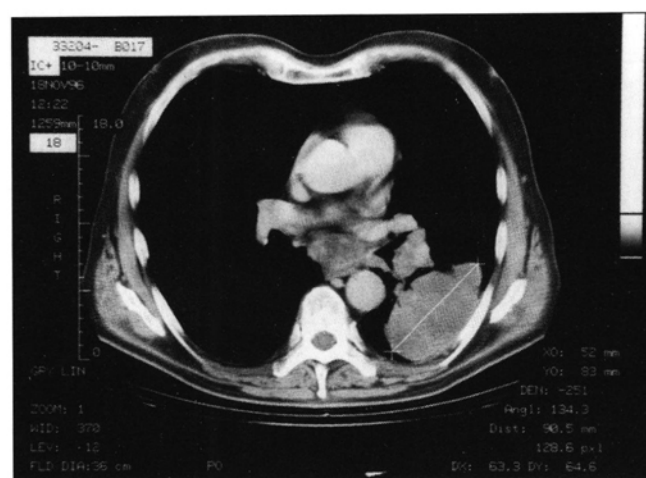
CT of the chest shows a large mass lesion in the superior segment of the left lower lobe with mediastinal and hilar adenopathy.
